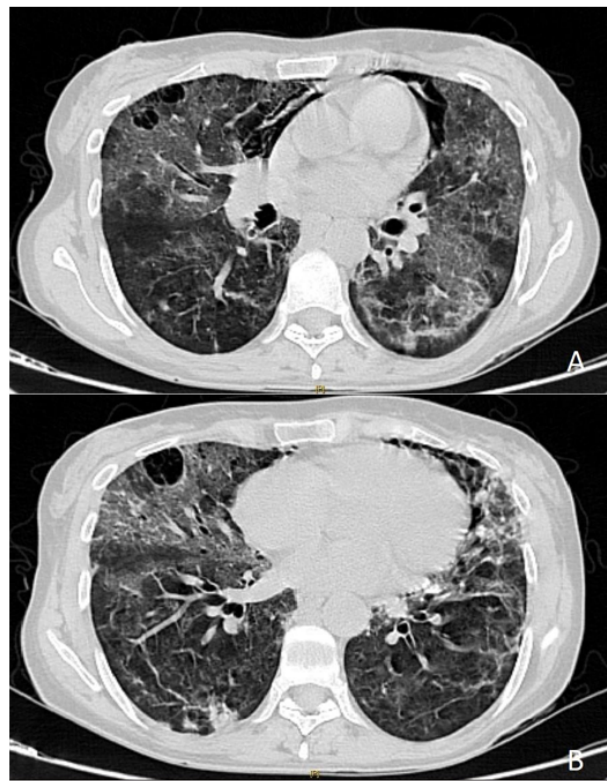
Figure A and B: CT imaging in axial section at different level in lung window, shows bilateral ground glass opacities and interstitial infiltration with some cystic lesions, complicated by pneumomediastinum (A and B).
